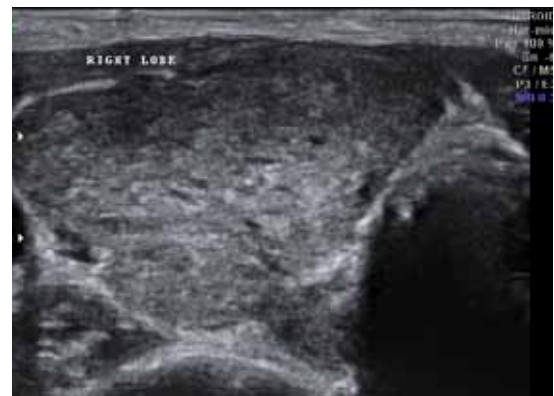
Ultrasound demonstrating enlarged right thyroid lobe with heterogenous echotexture and multiple small hypoechoic nodules and coarse echogenic septations.
